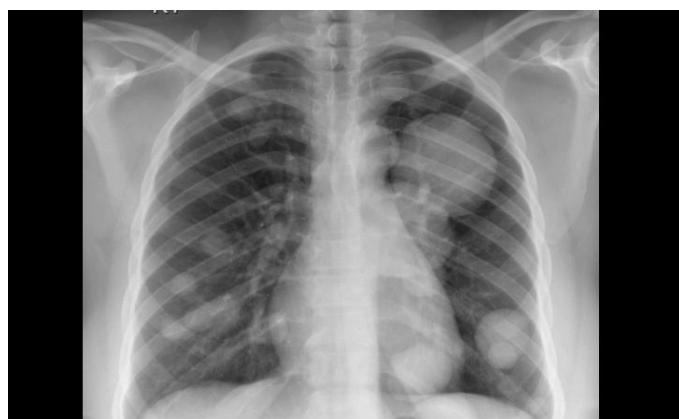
Chest radiograph of PBML
